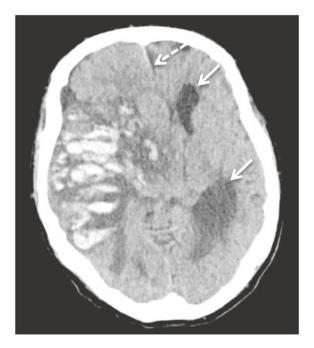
A 72 year old man on warfarin presented after a fall at home. On presentation to the Emergency Department, he had left sided weakness and a reduced level of consciousness (GCS of 12). A non-contrast CT brain was performed. This axial image demonstrates a large acute intra-parenchymal haemorrhage (white areas on the right side of the brain). The mass effect of the haemorrhage is causing subfalcine herniation—this is a form of herniation where part of the right side of the brain is pushed medially and below the falx cerebri (dashed arrow). There is resultant hydrocephalus of the left lateral ventricle (dashed arrow) due to compression of the third ventricle
